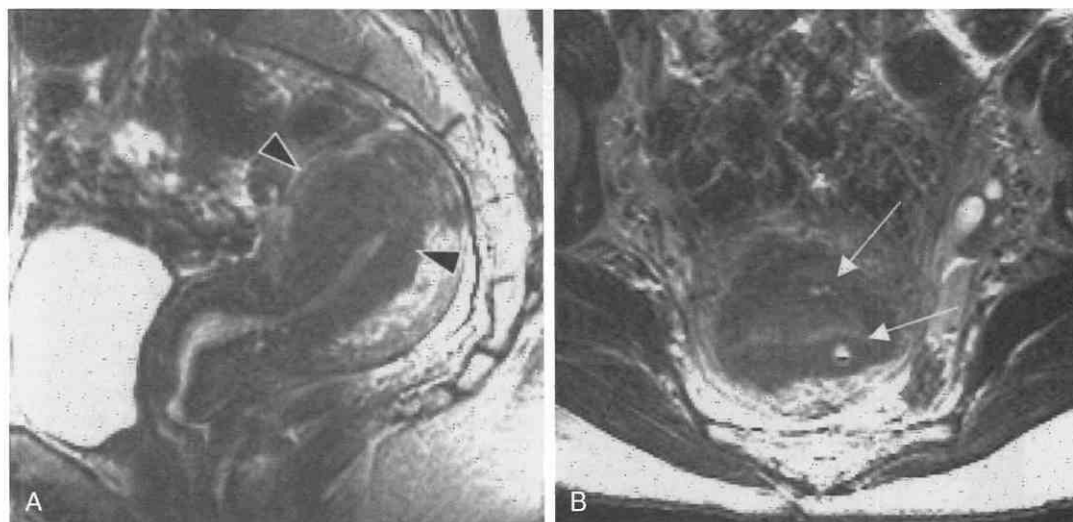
Adenomyosis. Sagittal T2-weighted, spin-echo (*A*) and axial T2-weighted (*B*) images demonstrate thickening of the junctional zone (arrowheads). Small, punctate, high-signal-intensity foci (arrows) represent endometrial glands. (From Outwater EK, Siegelman ES, Van Deerlin V: Adenomyosis: Current concepts and imaging considerations. *AJR Am J Roentgenol* 170: 437–441, 1998.²⁶³)
